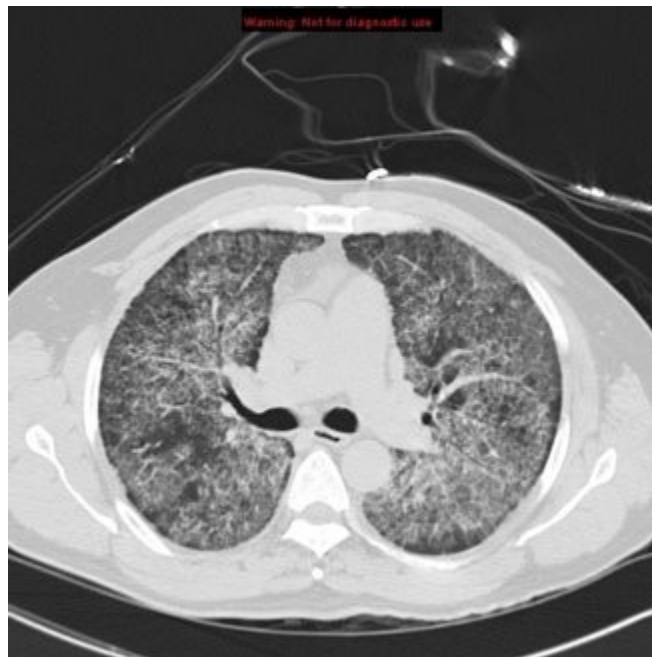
Non-contrast computerized tomography (CT) scan of his chest which is remarkable for diffuse ground glass opacities accompanied by thickened intralobular and interlobular septa in polygonal shapes.
